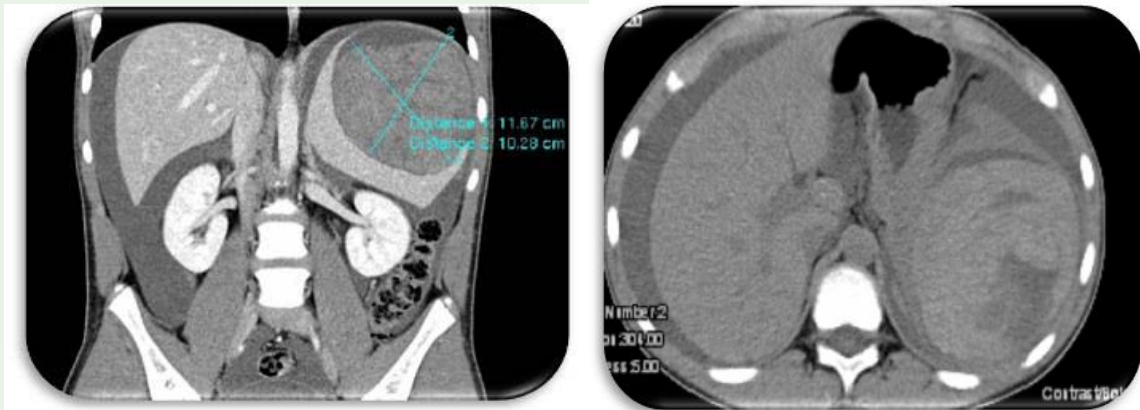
Detail of admission CT scan - hemoperitoneum evident in all peritoneal recesses and grade III splenic hematoma with estimated 12*10cm.
